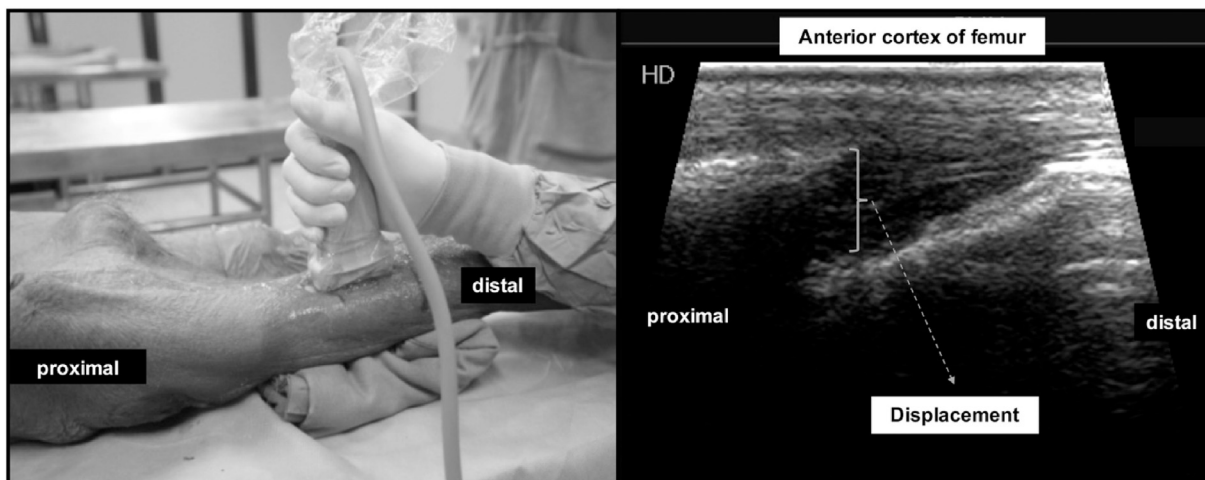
Ultrasound probe orientation in assessing fracture displacement in the anteroposterior (AP) direction.
